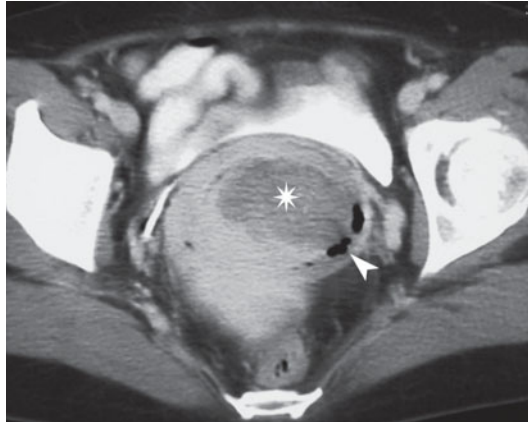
Computed tomography. Endometritis. Axial image acquired in the venous phase. The uterus is enlarged and occupied by heterogeneous material (*asterisk*) in which small bubbles of gas are apparent (*arrowhead*)
